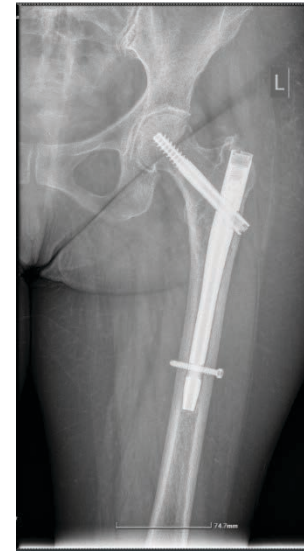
Post surgery radiographic image of lesion stabilization with intramedullary nail.
